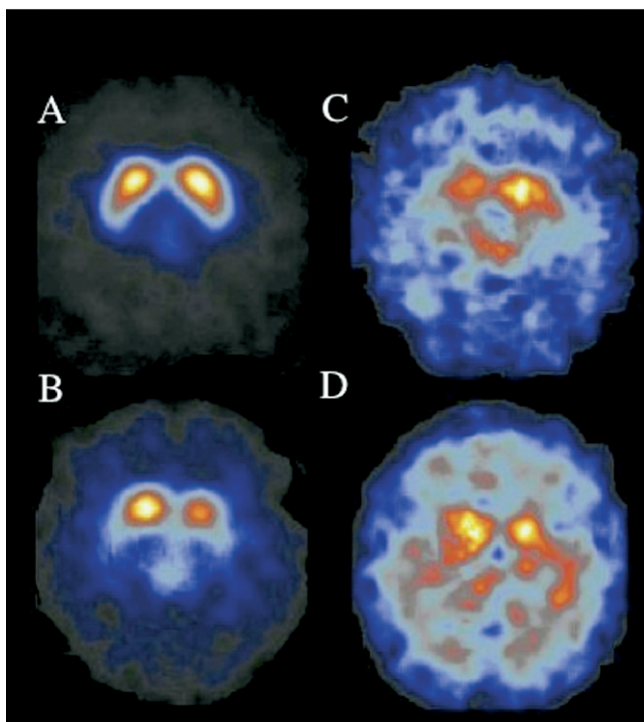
Transaxial SPECT images demonstrating dopamine transporter imaging in healthy control (A), Parkinson's (B) and the related Parkinson plus disorders of progressive supranuclear palsy (C) and multiple system atrophy (D). Presynaptic markers of dopamine function have been difficult to use in isolation from other clinical or imaging measures as a means to separate the parkinsonisms as all involve degenerative changes in the dopaminergic projections to the striata.
